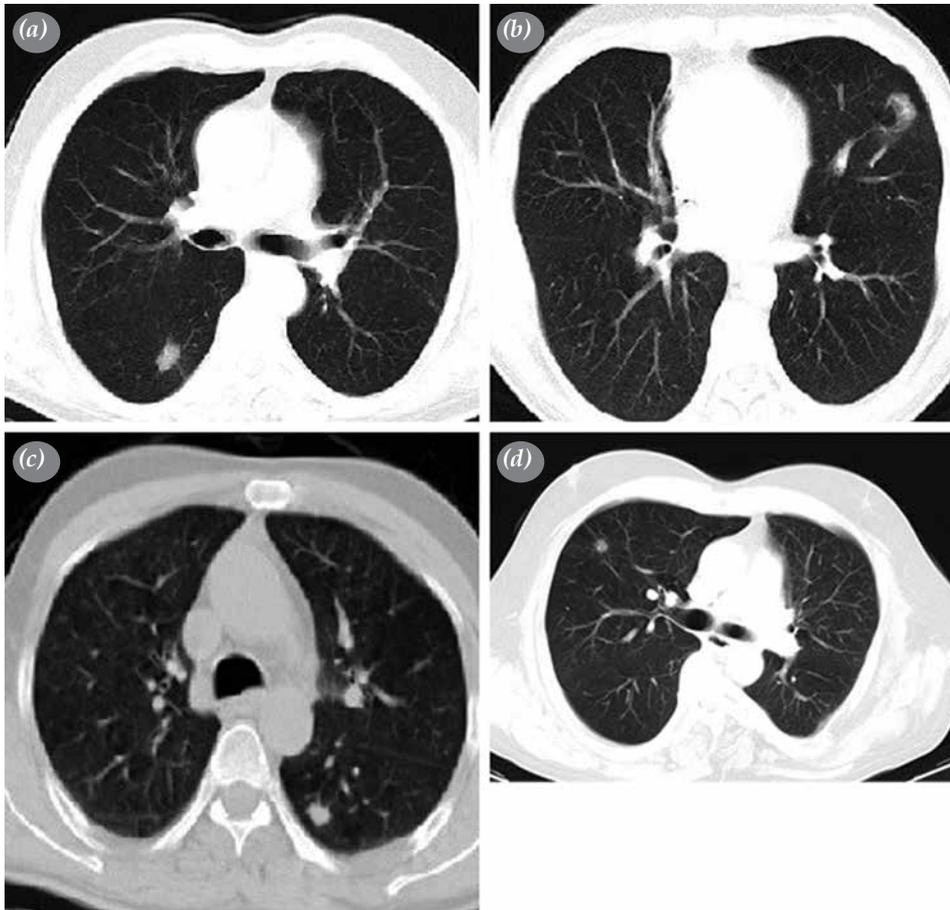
Computed tomography images of malignant lesions. (a) Right upper lobe adenocarcinoma. (b, c) Left upper lobe adenocarcinoma. (d) Right middle lobe squamous cell carcinoma.
